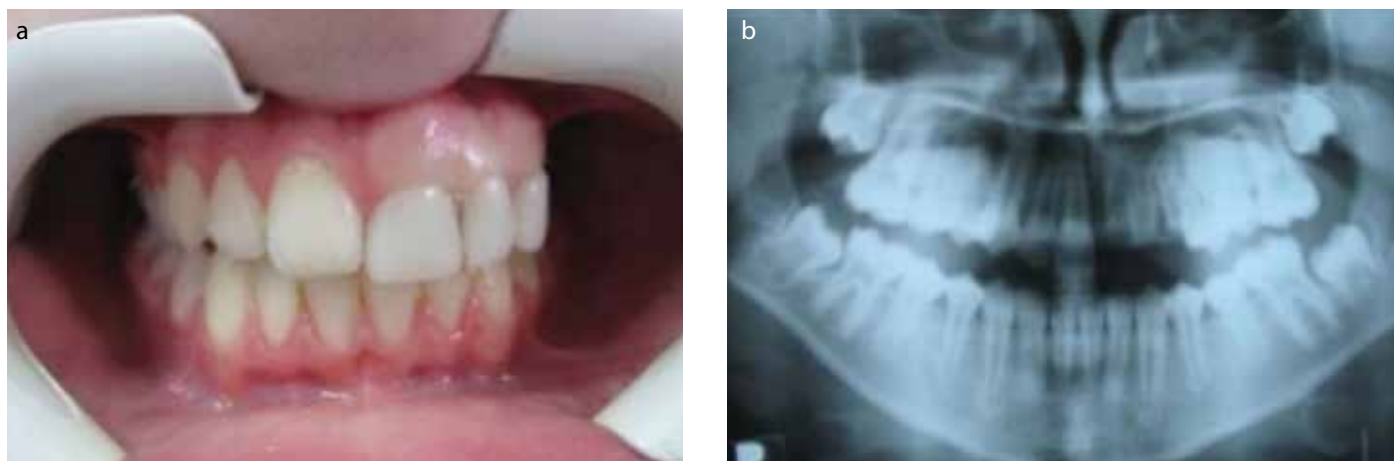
a, b. (a) Temporary prosthetic rehabilitation (b) 1 year follow-up panoramic radiograph.
